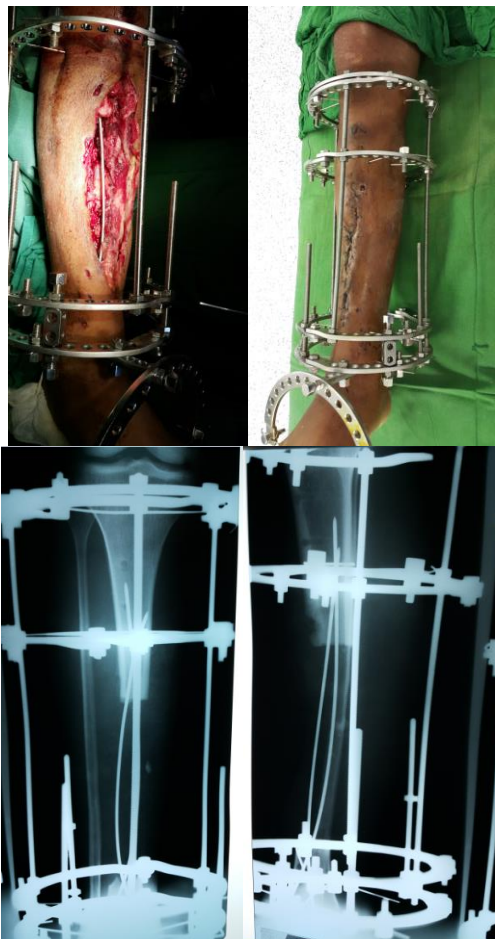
Postoperative radiograph and clinical photograph demonstrating the application of the Ilizarov circular frame, utilizing flexible intramedullary K-wires as guides for the transported bone segment.
